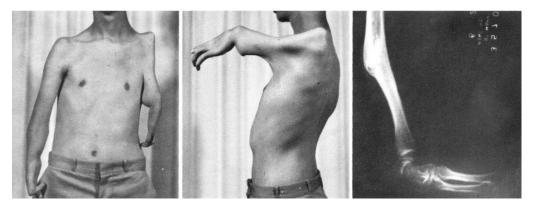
Left, the short left upper limb is phocomelic. Note the severe atrophy of the left shoulder girdle. There are three digits in the hand. The right arm (ulnar hemimelia) demonstrates good shoulder musculature and mon tion. Center, abduction and forward flexion are limited by the axillary web. Right, X-rays reveal fused right radiohumeral joint (failure of cavitation).
